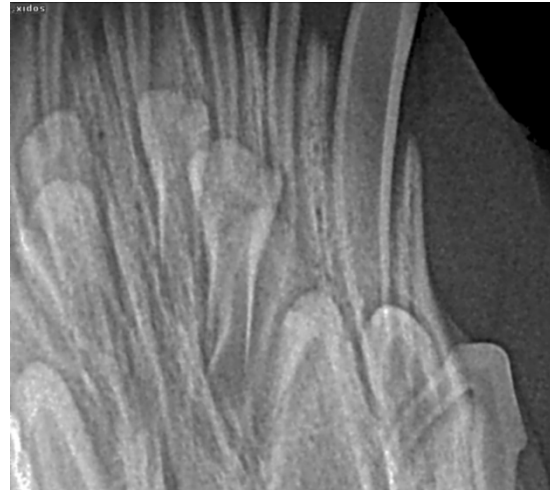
The required pre-op intra-oral dental radiograph.
